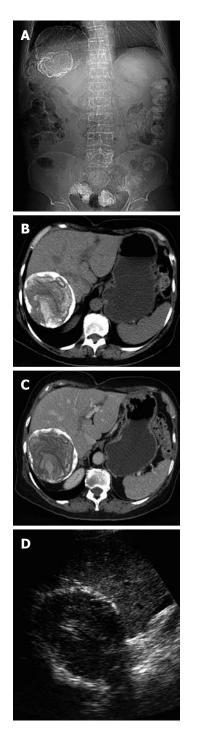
Calcified unilocular hydatid cyst. Digital scout image (A) shows a round, densely calcified lesion supra-elevating the right diaphragm. Computed tomography basal (B) and contrast-enhanced (C) images reveal a hypoattenuating lesion with peripheral wall calcification in the right lobe. Membranes appear as serpentine linear structures. Note the complex ultrasonography aspect of the cyst and the hyperechoic wall (D).
